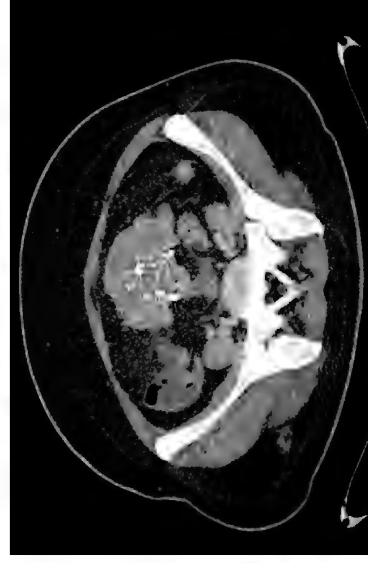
Axial CT image shows a pelvic mass with enhanced rim. Beam hardening artefacts is noted around the radioopaque markers.
